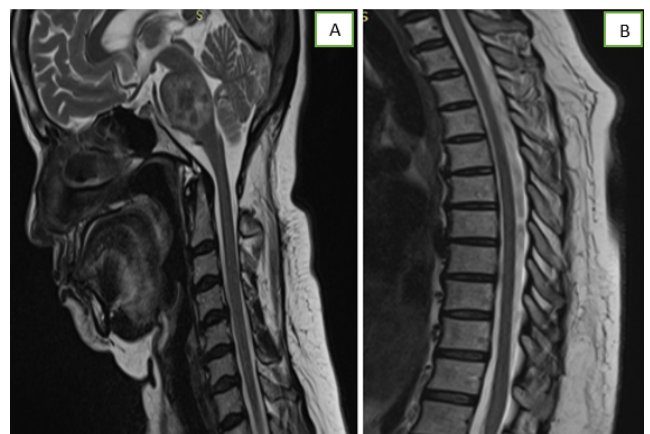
A,B: MRI cervical spine and dorsal spine, Sagittal T2 weighted sequence, shows normal cervical and dorsal spine.
